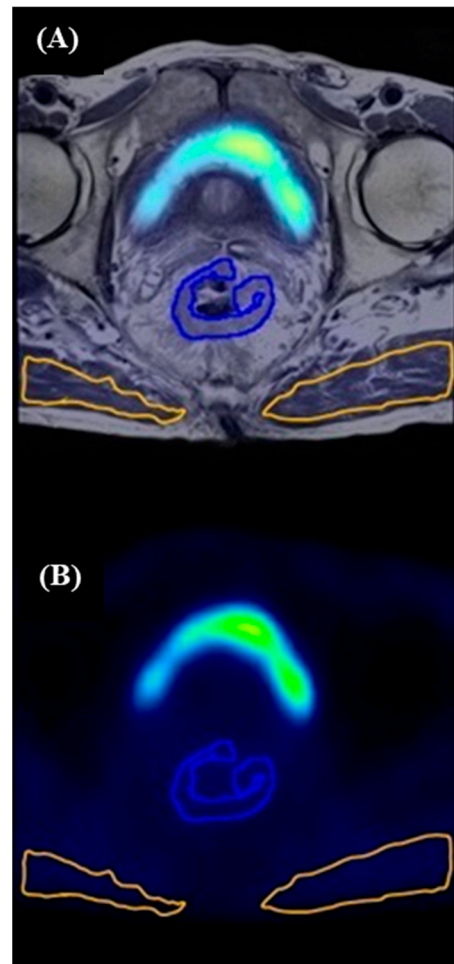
Segmentation method guided with T₂-weighted MR image fused with ¹⁸F-FAZA PET image (A) and corresponding ROI in ¹⁸F-FAZA PET image alone (B). Segmentation method. Axial T₂-weighted MR image at the level of mid-rectum with tumor segmented (blue contour) and gluteus maximum muscle segmented bilaterally (orange contour).
